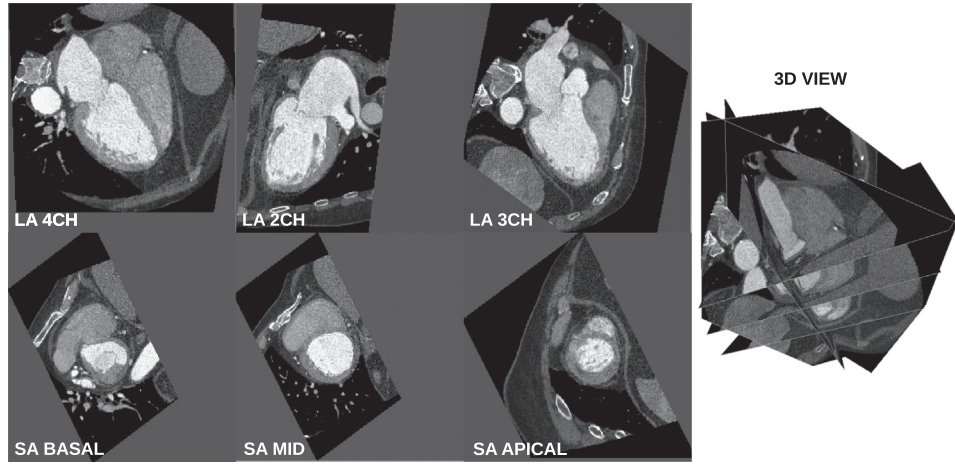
LA and SA projections extracted from CT after CT-MR rigid registration.
